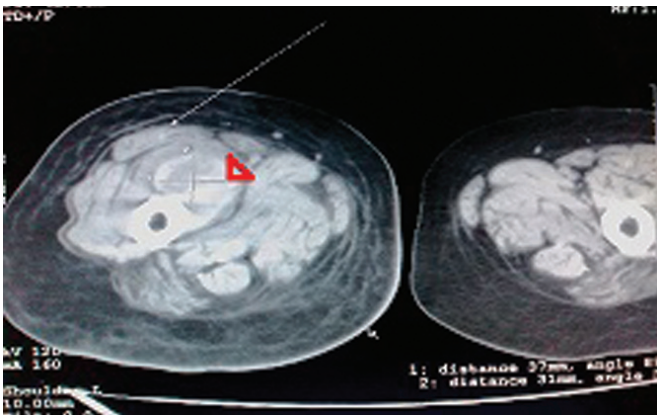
CT scan of right thigh showing bulky muscles with hematoma
